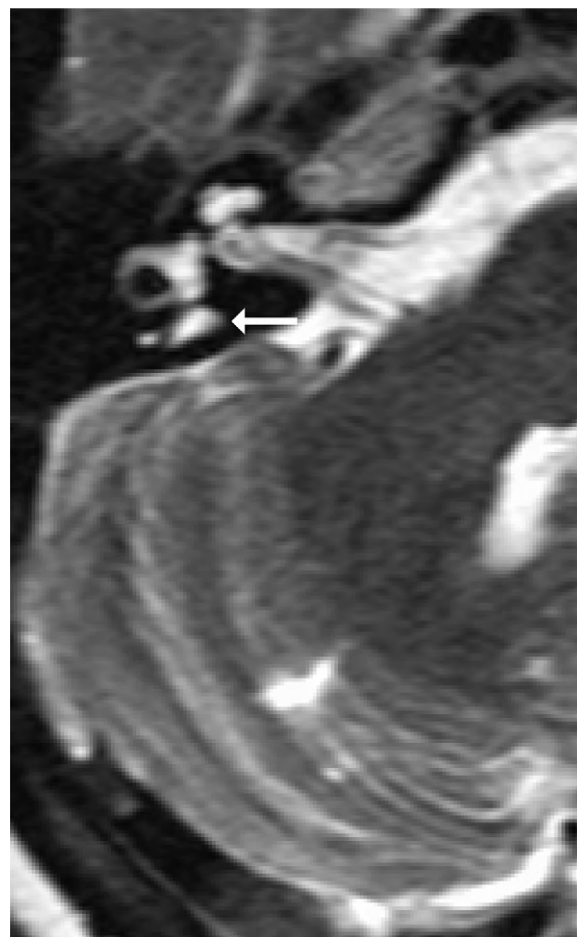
On MRI, the large right vestibular aqueduct is typically hyper intense (white arrow).
